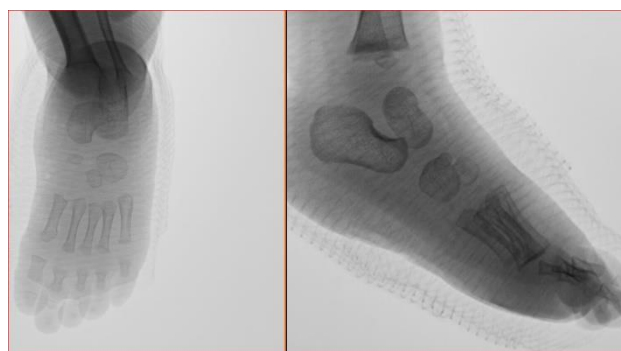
Postoperative radiographic examination of the left foot at the 6th week after surgery.
